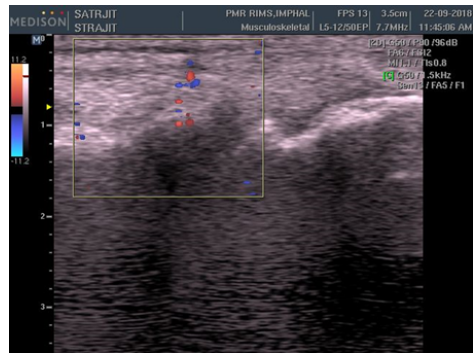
Ultrasound image showing neovascularization
